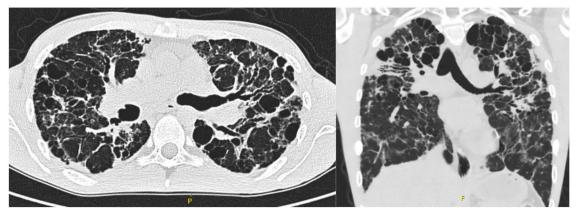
Date: 08-2020: Transverse (Left) and Coronal (Right) of chest computed tomographic (CT) scan, done 14 months after the second transplant, and showing severe upper and mid-lung zones predominant bronchiectatic changes in peri-bronchovascular and peripheral distribution, along with bilateral and extensive upper lobe predominant cysts. The significant decrease in ground glass opacities visualized on previous imaging is indicative of the decrease in inflammatory component of the patient's progressive lung damage.
